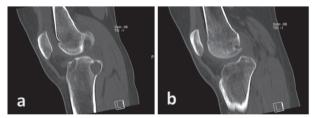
(A and B): Coronal Non-Contrast CT Scan of Right Knee: (A) A Large Well-Defined Subchondral Cyst Seen in the Posterior Aspect of Medial Tibial Plateau Showing Minimal Bone Expansion, Thinning and Scalloping of Posterior Cortical Bone. It Has Narrow Zone of Transition. No Associated Periosseus Soft Tissue Component Could Be Detected. Another Smaller one seen close to Tibial Spine Anterior Aspect (B) Shows Much Smaller Similar Cyst close to Femoral Condyle
